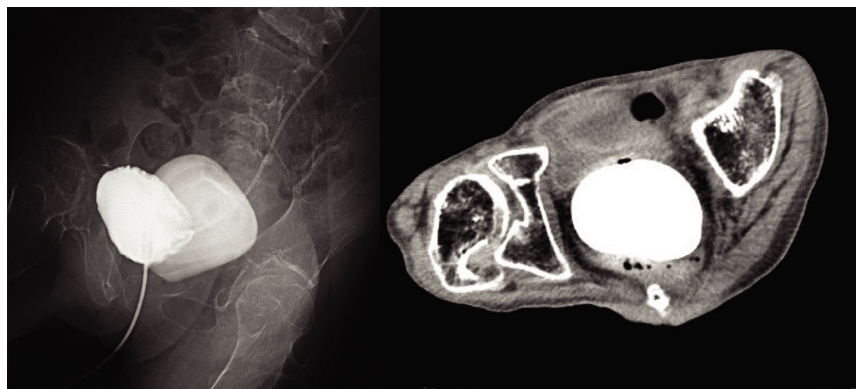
Abdominal CT shows a calculus in the pelvis, measuring $8.1 \times 5.6 \times 7.0$ cm. The calculus is posterior to the bladder and anterior to the rectum. Cystography shows a stone posterior to the bladder with no evidence of a fistula between the bladder and the vagina.
